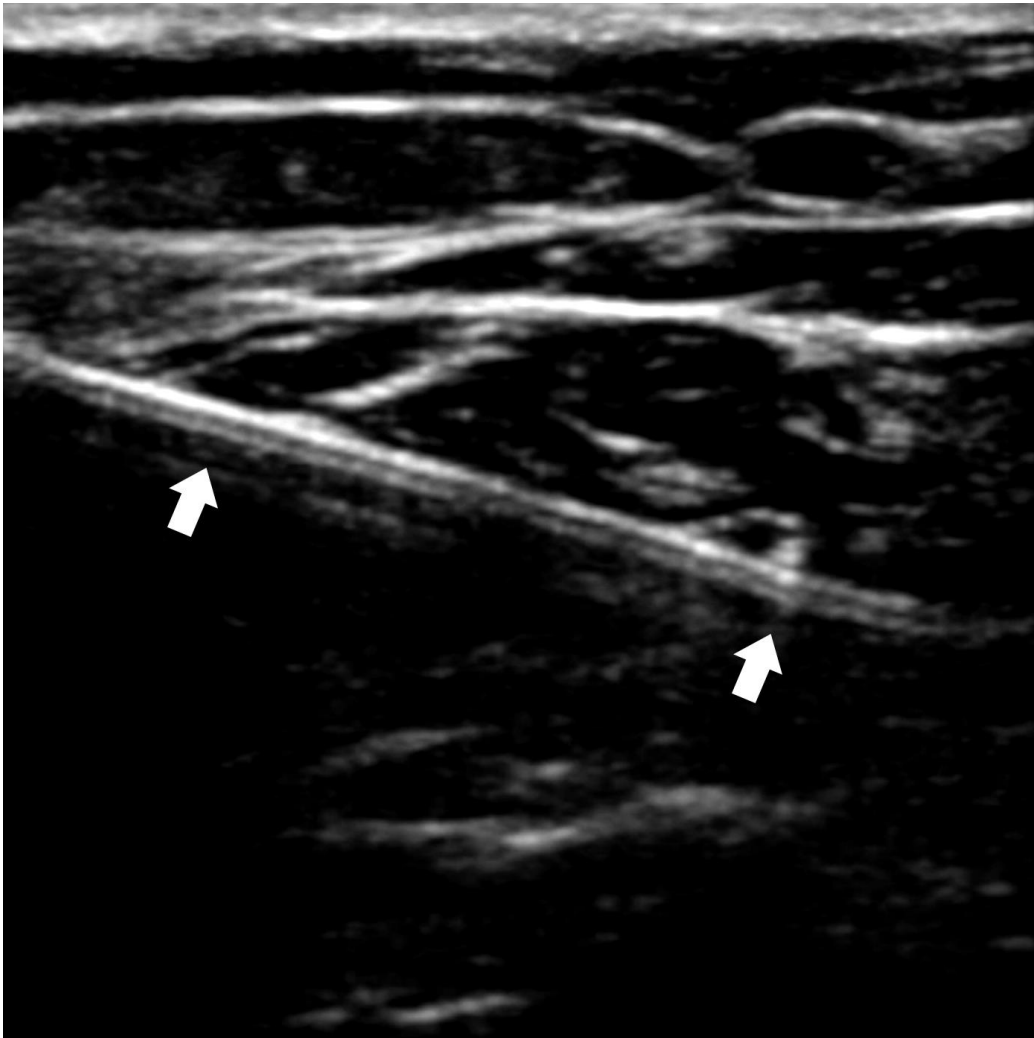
Ultrasound image of soft tissue foreign body (arrows) in longitudinal axis.
